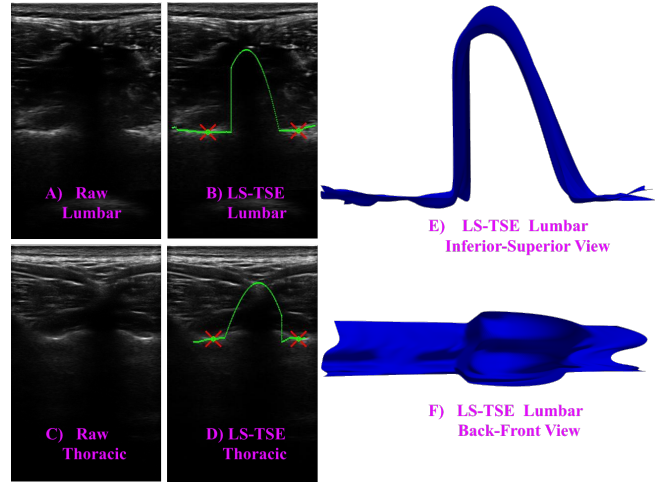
Vertebral surface extraction from human transverse spinal ultrasound using LS-TSE. In panels A~D, red crosses denote the lamina landmarks and green curves represent the bone surface. Images E/F present the B-Spline 3D mesh of an extracted lumbar vertebral surface.
